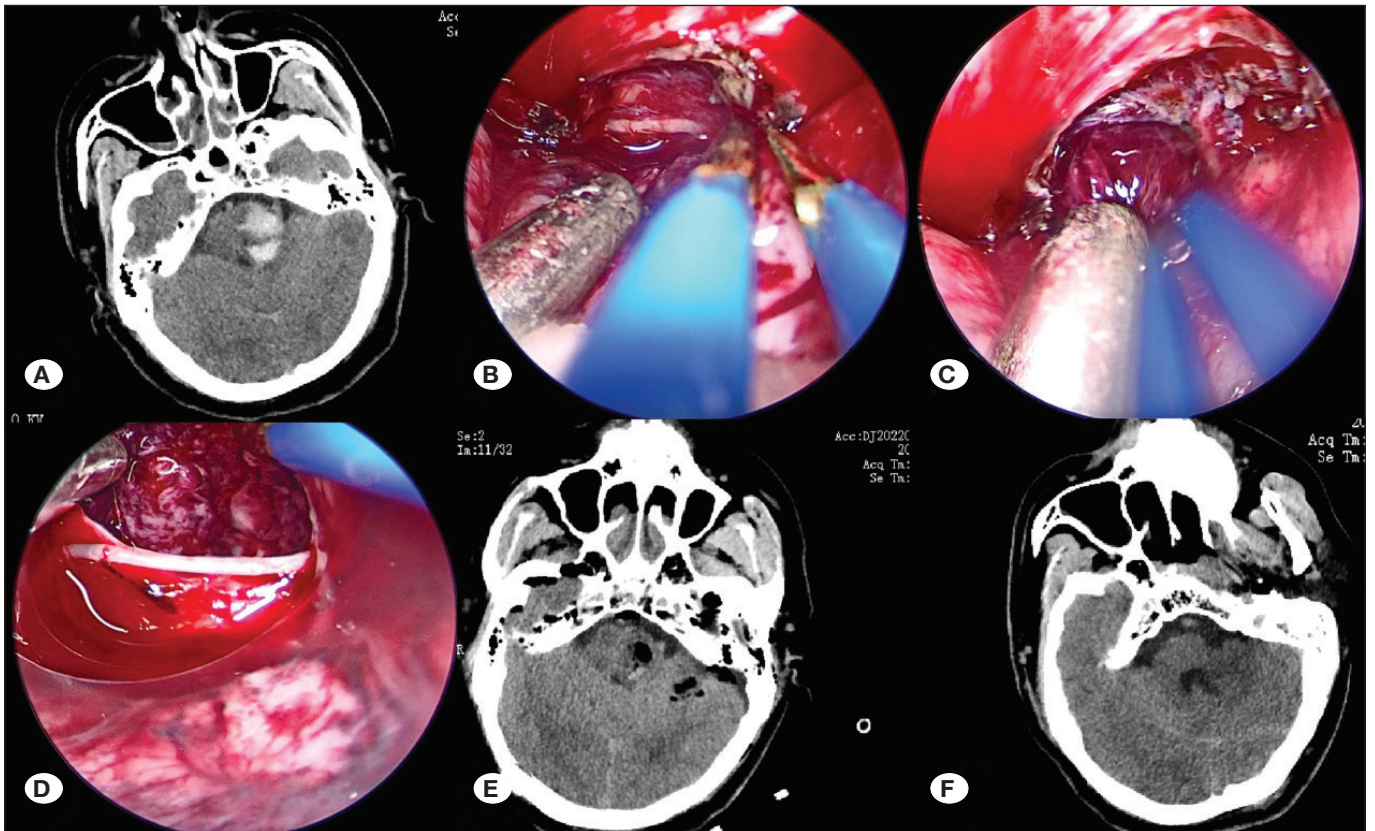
Preoperative head computed tomography (CT) showed that the largest level of the hematoma was located in the left pontine region (A). The tentorium of the cerebellum was cut and the brainstem structure was exposed (B). The hematoma was removed by neuroendoscopy (C). Examination of the hematoma cavity showed no obvious active bleeding (D). CT examination of the head within 24 hours revealed satisfactory hematoma clearance after surgery (E). CT examination of the head one month after surgery (F).
